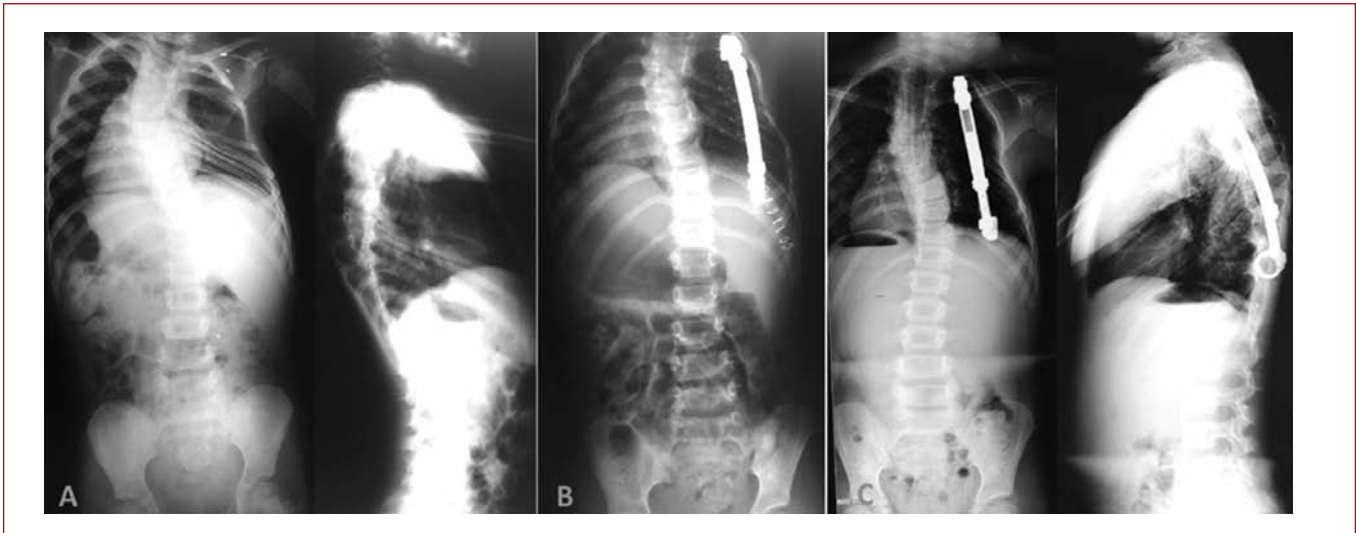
a. Preoperative anteroposterior and lateral X-rays, b. postoperative anteroposterior X-ray, c. anteroposterior and lateral X-rays after the follow-up period.
